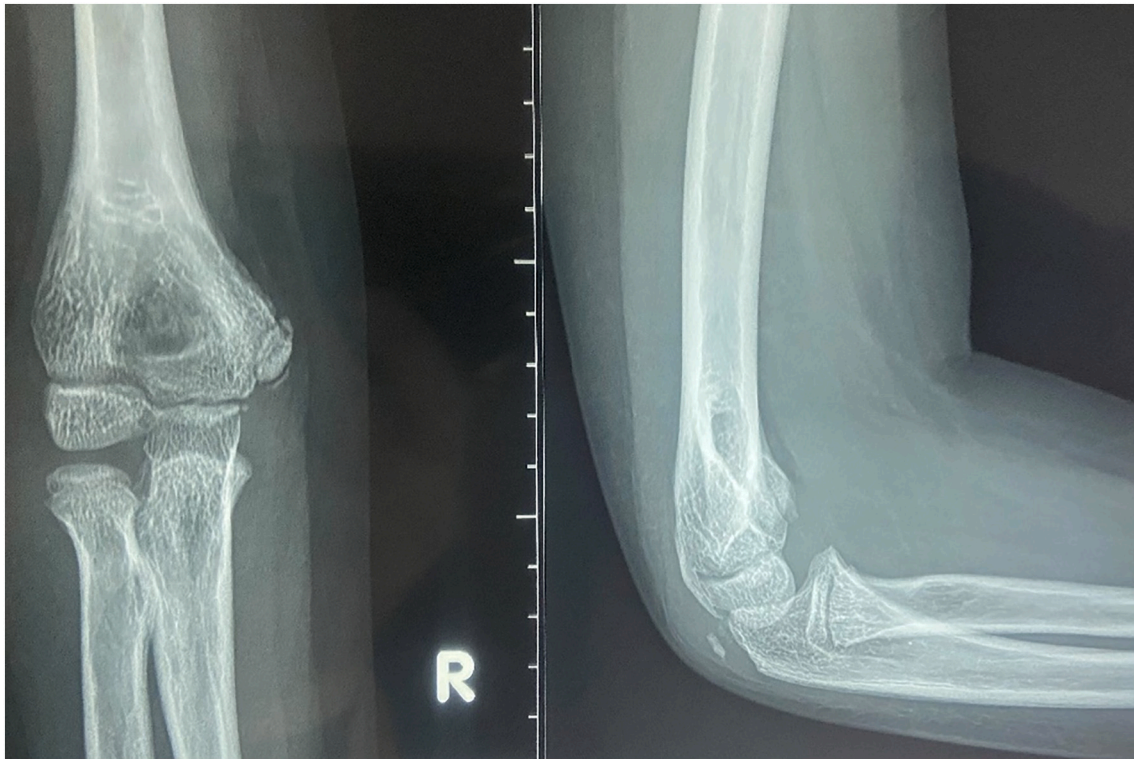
Shows anteroposterior and lateral views of radiographs show healed medial epicondylar avulsion.
